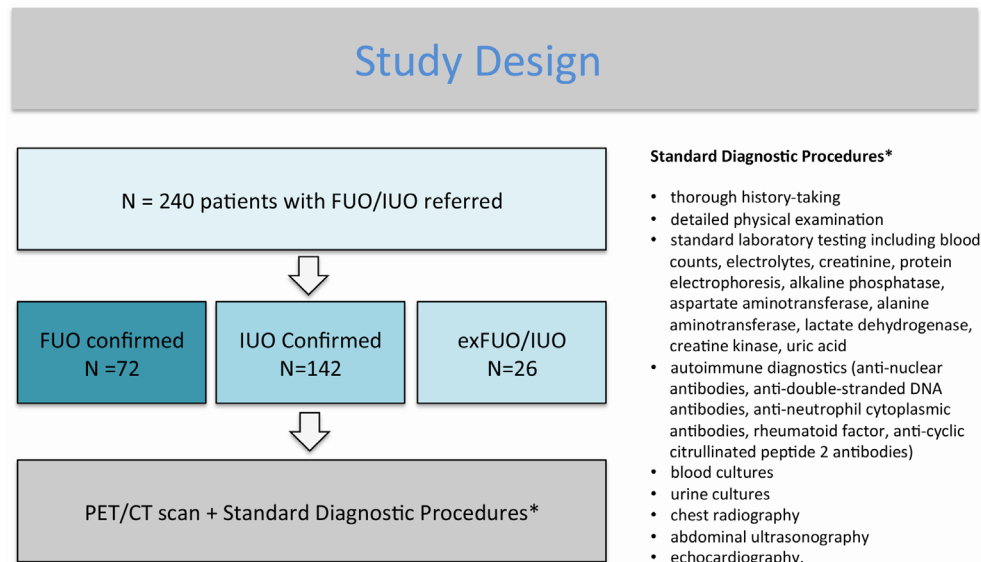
Study design. Patients with either FUO or IUO were referred. At referral, diagnosis of FUO or IUO was confirmed. Patients not fulfilling FUO or IUO criteria at the time of admission were termed patients with exFUO/IUO. All patients received ^{18}F -fluorodesoxyglucose positron emission tomography/CT scanning and a standard diagnostic procedure as outlined. FUO, fever of unknown origin; IUO, inflammation of unknown origin; PET, positron emission tomography.
